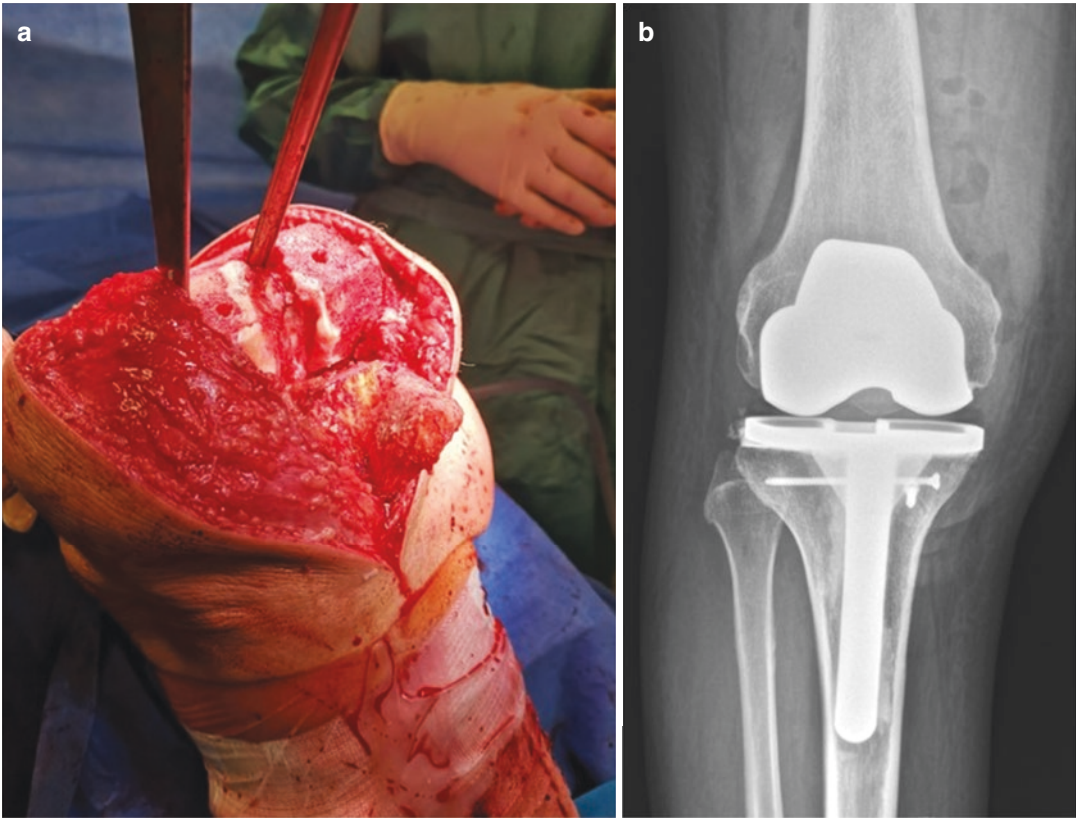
Intraoperative fracture of the anterior tibia when impacting the tibial component (a), radiographic follow-up showing the refixation of the fragment by using a screw (b)
